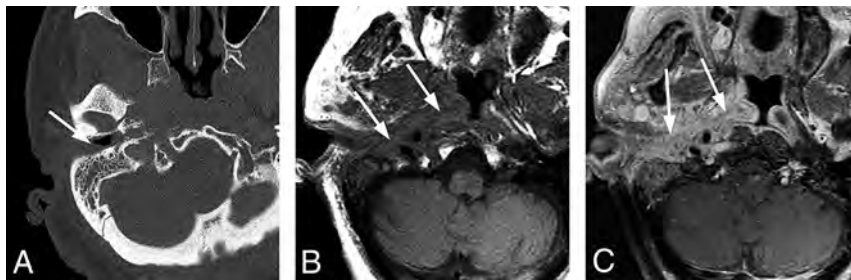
Typical SBO from NEO. An 82-year-old woman with insulin-dependent diabetes presented with a several-month history of pain and drainage from the right ear. The patient was recently treated as an outpatient with several rounds of antibiotics (including amoxicillin/clavulanate and ciprofloxacin) for otitis media and NEO, but symptoms had progressed. Following imaging and a diagnosis of SBO, the patient was treated with 4 weeks of IV vancomycin and piperacillin/tazobactam and additional 4 weeks of oral ciprofloxacin. The patient initially had clinical improvement, but a gallium scan at 8 weeks showed persistent uptake. The patient did not return for follow-up as instructed but returned 8 months after the original admission with progressive infection extending to the central skull base and left temporal bone, requiring an additional 6 weeks of IV antibiotic treatment. A, Axial CT scan through the right EAC demonstrates thickening and partial opacification of the external auditory canal (arrow). There is subtle erosion along the posterior wall of the external auditory canal and mild soft-tissue fullness of the right nasopharynx. B, Axial T1-weighted MR image demonstrates obliteration of normal fat planes in the submucosal and preclival tissues of the nasopharynx (arrows). This process extends posterolaterally to the tip of the mastoid on the right. C, Axial T1-weighted contrast-enhanced image demonstrates heterogeneous enhancement of abnormal tissue extending from the tip of the mastoid on the right to the nasopharynx (arrows) without discrete abscess formation.
